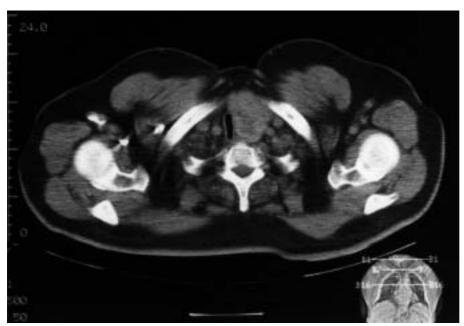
Computed tomographic scan at the level of the thoracic inlet in Case No. 2. The trachea is narrowed and deviated to the right by an enlarged thyroid gland.
